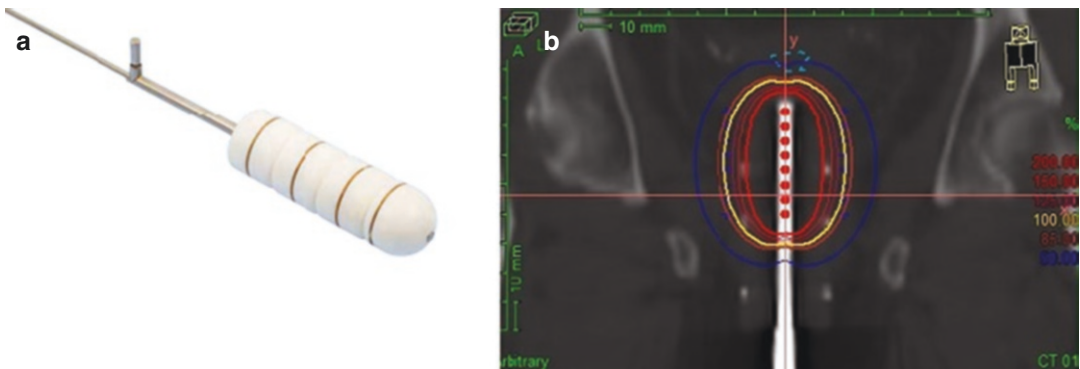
(a) A segmented single-channel vaginal cylinder applicator used for adjuvant vaginal vault brachytherapy. (b) The dosimetry of a brachytherapy treatment using the same applicator on a localization planning CT scan. Red
